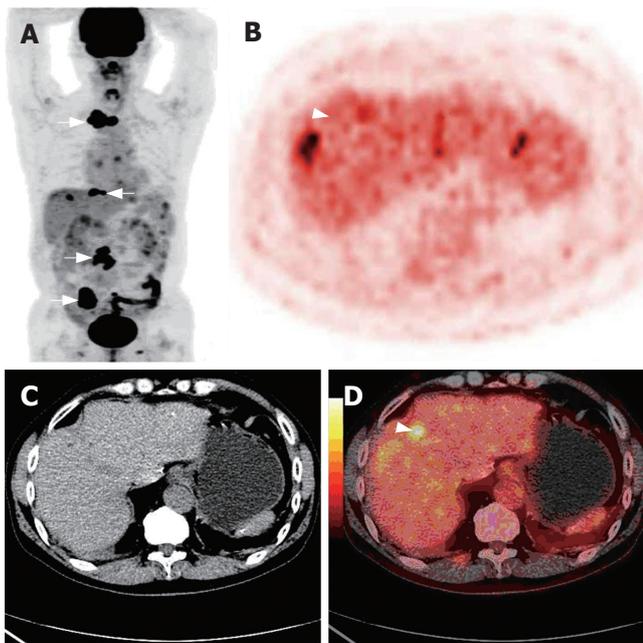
A 68-year-old male undergoing HCC resection 28-mo ago. Multiples bone metastases (arrow) on the image of whole body PET (A), non-enhanced CT (C) detecting no recurrence lesion in the liver, ^{18}F -FDG PET (B) and PET/CT fused imaging (D) showing a high metabolism recurrent lesion (arrow head).
